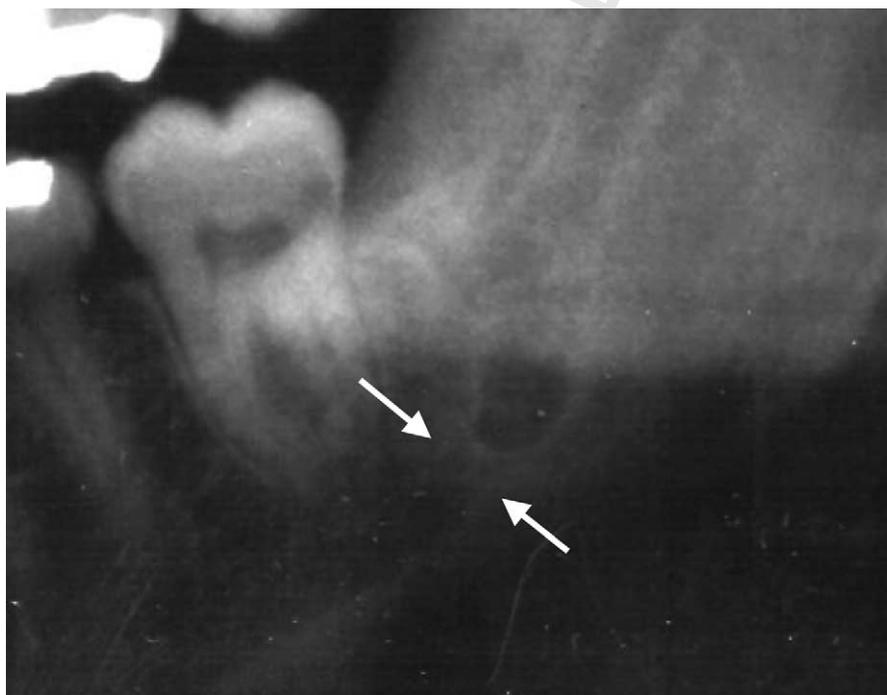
Radiograph taken 23 months after removal of a third molar. The mandibular canal is disrupted with little evidence of continuity either radiographically or at the time of subsequent exploration. The white arrows indicate an area of bone formation across the site of the original canal with a cortical outline to the proximal section.
